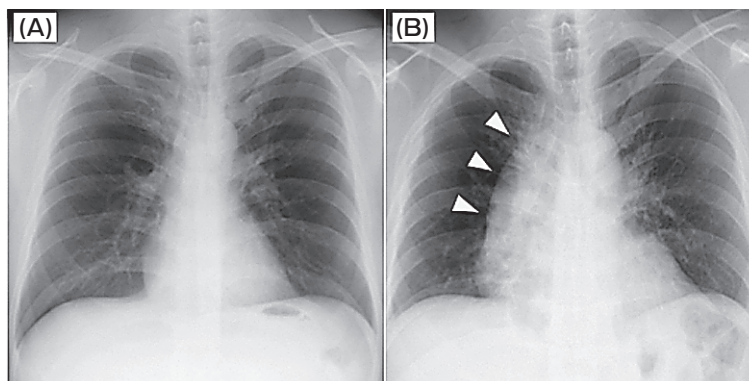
Chest X-ray (A) 3 years before the onset and (B) at the time of the patient's present hospitalization. The right mediastinal shadow was enlarged (arrowhead).
